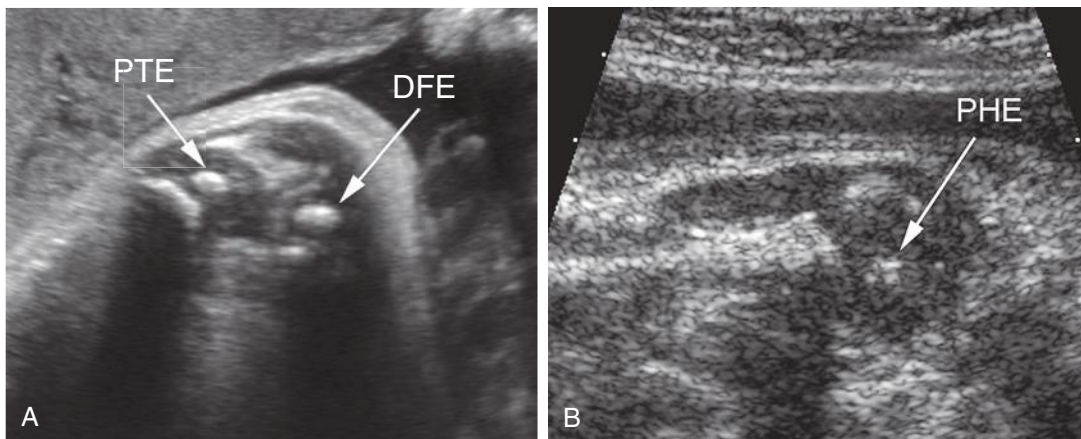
A, Coronal sonogram of the distal thigh in a term fetus. Note the large and similar sizes of the ossification centers, a virtually certain sign of a near-term fetus. B, Coronal sonogram through the proximal humerus shows an early secondary ossification center in the humeral head, another finding indicating a later gestation. DFE, ossification center of distal femoral epiphysis; PHE, ossification center of proximal humeral epiphysis; PTE, ossification center of proximal tibial epiphysis.
